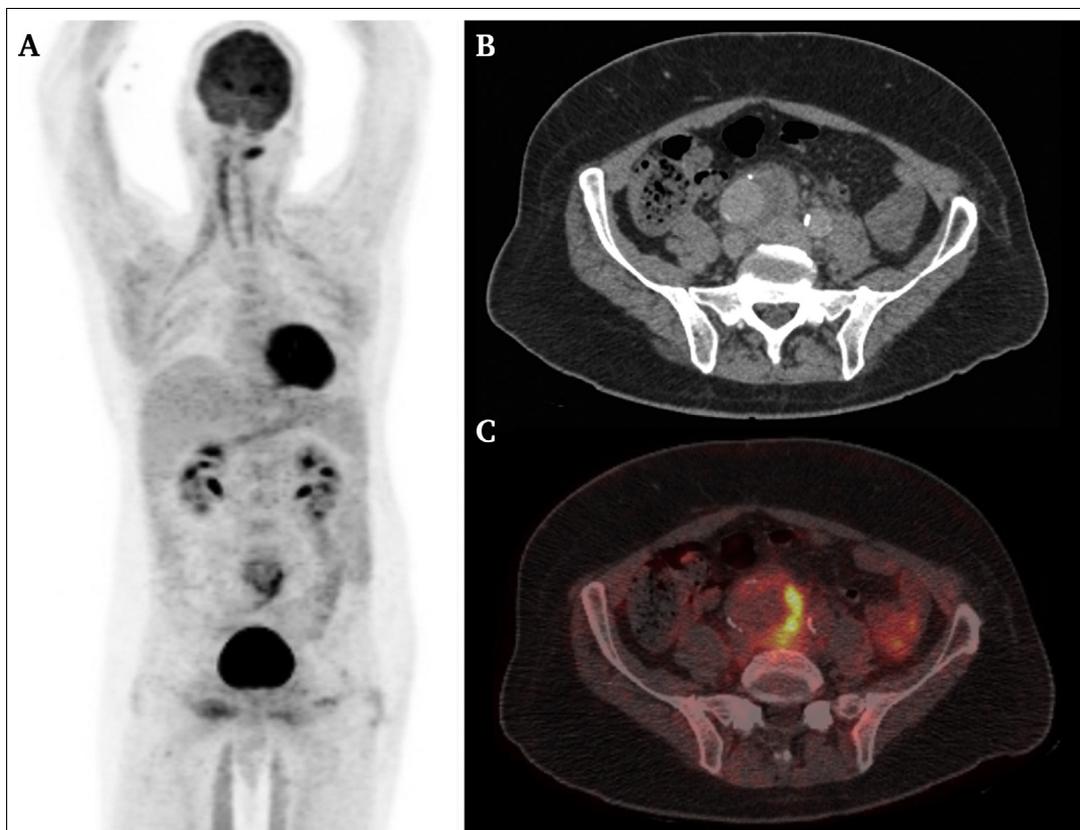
A 48 year old male patient presented with fever and abdominal pain, and was diagnosed with an infected aortic aneurysm caused by *Staphylococcus aureus*. Maximum intensity reconstructions of positron emission tomography (PET) (A) and fused PET/computed tomography (CT) images (C) showed strongly increased, focal ^{18}F -fluorodeoxyglucose (FDG) uptake in the abdominal aortic aneurysm wall, while contrast enhanced CT (B) showed mild thickening and mild contrast enhancement in the wall of the aneurysm. Both PET readers rated the examination true positive for an infected aneurysm, and both stated they were confident about their diagnosis. Only one reader of contrast enhanced CT rated the examination true positive, the other false negative; however, the latter was not confident about his findings.
